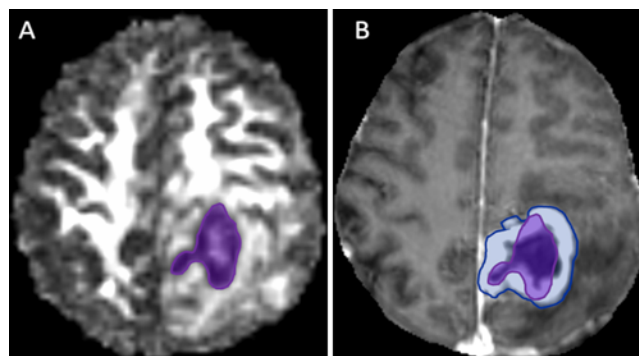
A demonstration of ROIs in a DTI-q image (A) and postcontrast T1-weighted image (B). The q-ROI (purple) shows the abnormality revealed on a DTI-q map. The CE-ROI (blue) is a CE tumor region excluding the DTI-q abnormality. Figure is available in color online only.
